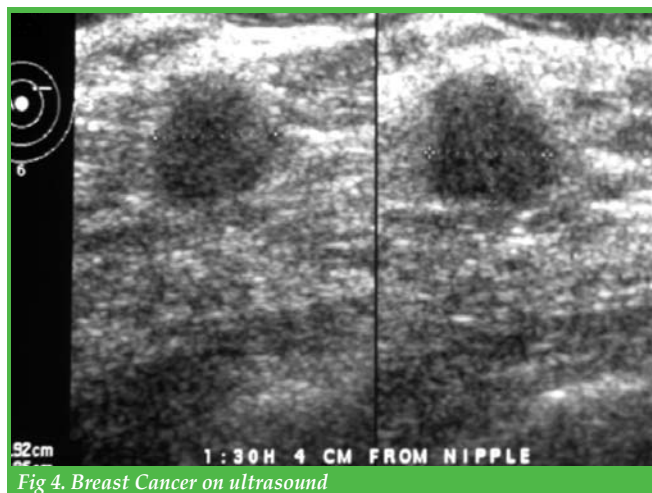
Breast Cancer on ultrasound
